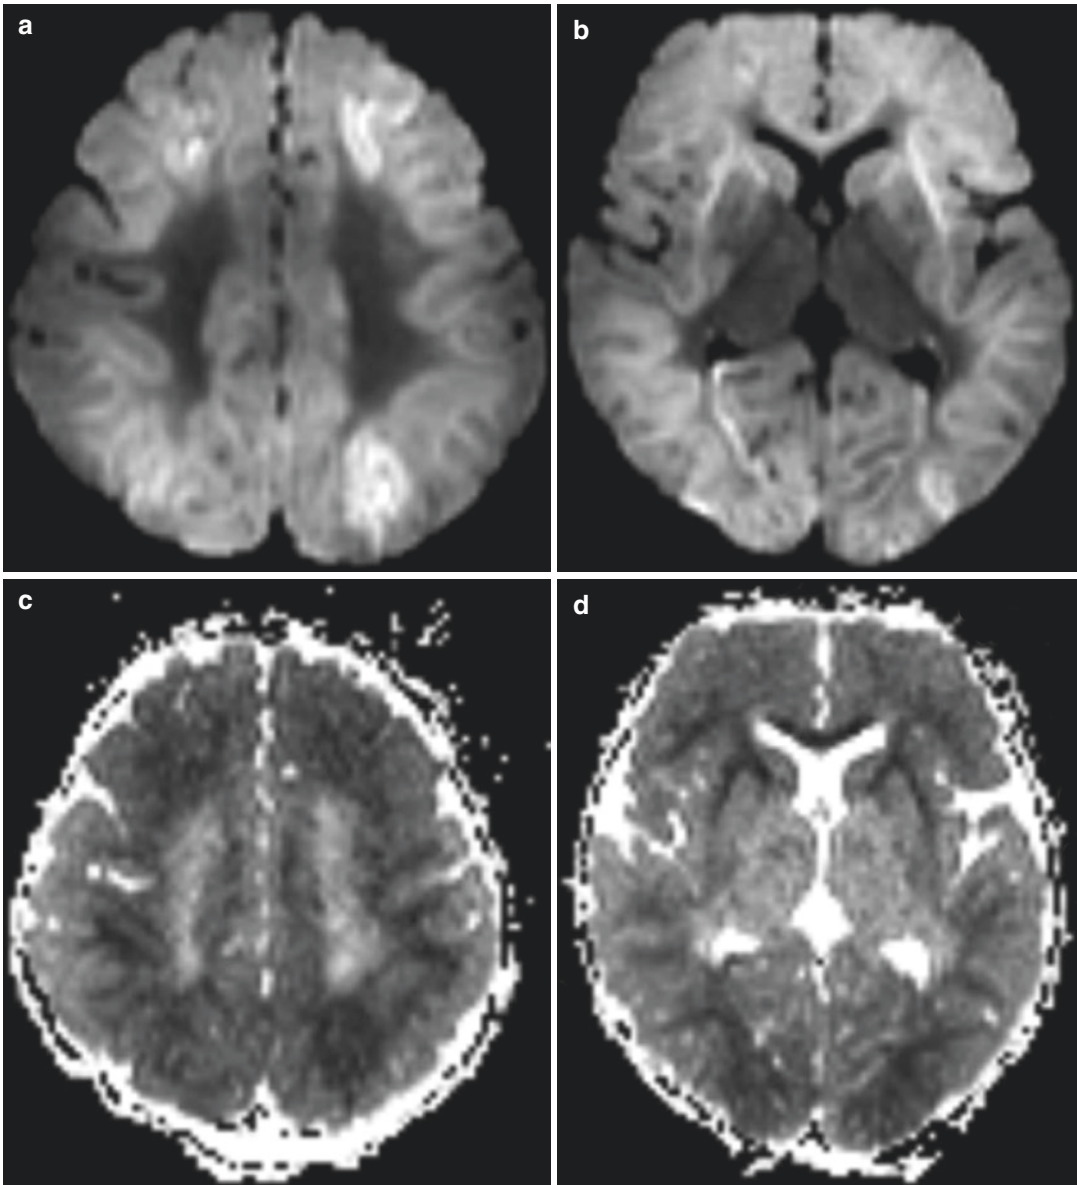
DWI (a and b) and ADC (c and d) maps demonstrating a watershed-type injury to the brain, also involving white matter and parts of the cortex with relative sparing of the basal ganglia, thalami and other parts of the cortex
